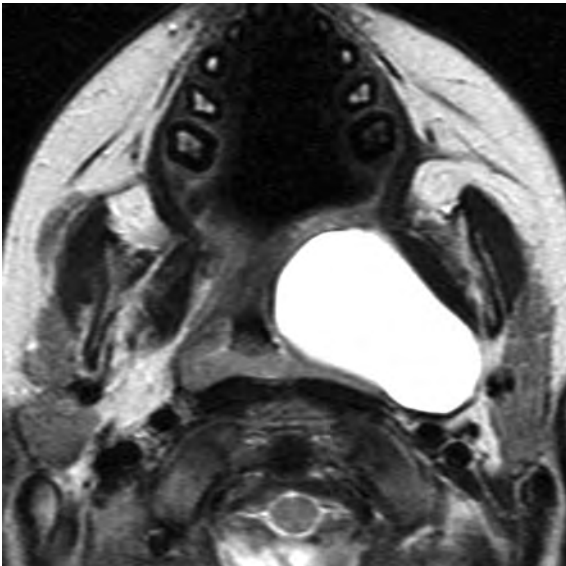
Young child presenting with peritonsillar swelling. Axial T2-weighted spin echo image shows a cystic mass in the prestyloid compartment of the PPS, displacing the pharyngeal wall. The cyst was resected and confirmed to be a branchio-genic cyst
